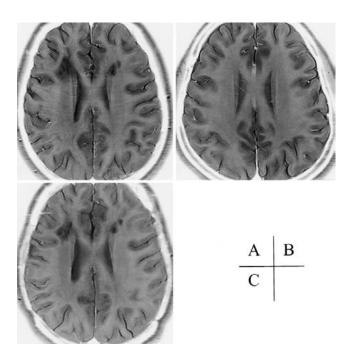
Axial MR images obtained in a 17-year-old woman with moyamoya disease before treatment (A) and after revascularization surgery (C). Note the high density of medullary streaks, which is more marked in the right hemisphere. An axial MR image obtained in a 19-year-old healthy volunteer is shown for comparison (B).
